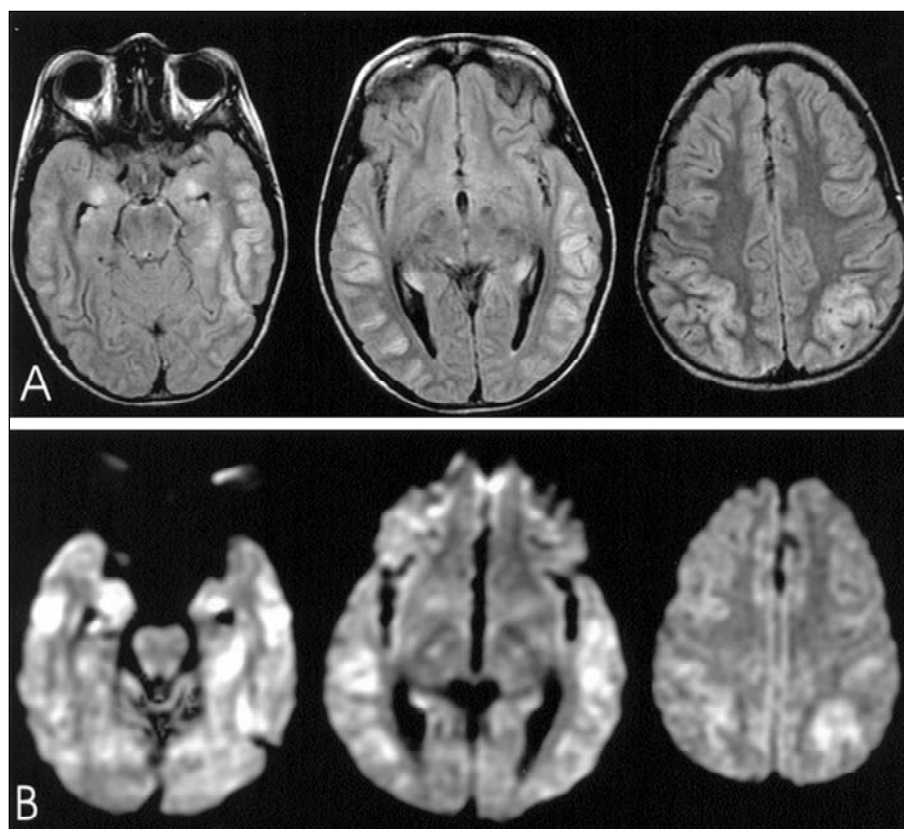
(A) FLAIR images demonstrating diffuse high signal in the cortical and subcortical regions of the temporal, parietal and occipital lobes. (B) DWI also show high signal in the same areas demonstrated in the FLAIR images.
